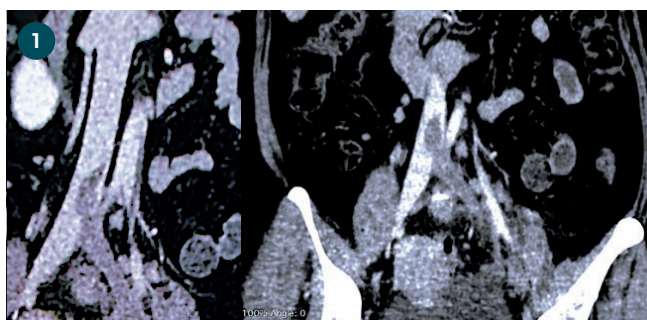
Computed tomography with image of the thrombus in the left common iliac vein and vena cava
